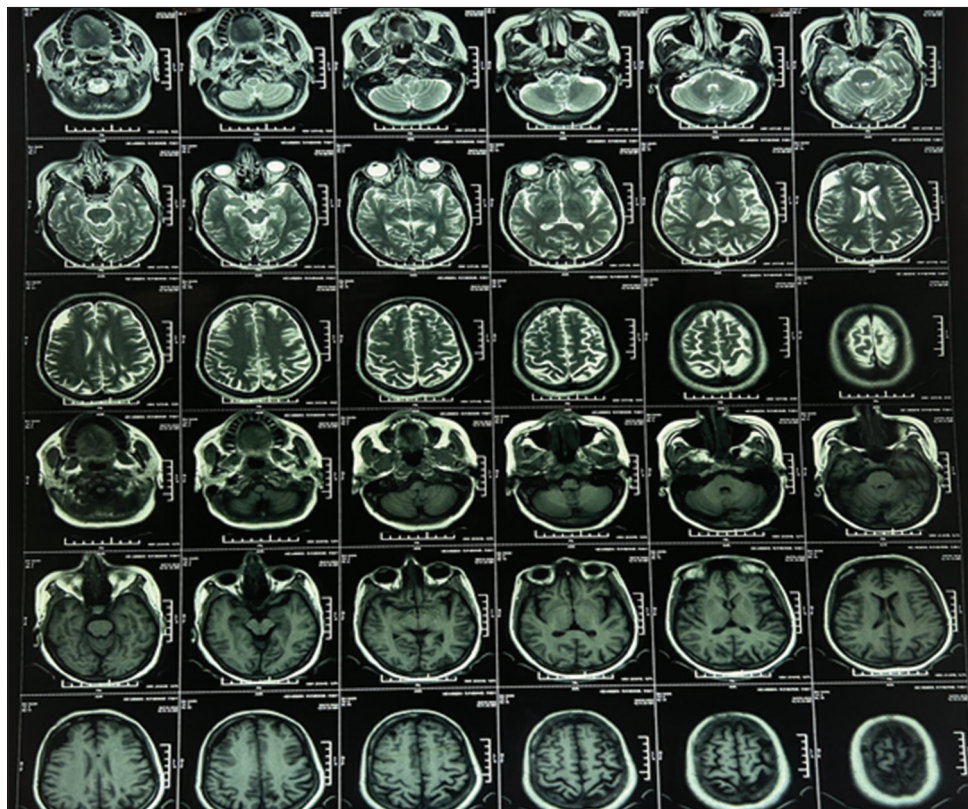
Magnetic resonance imaging of the brain showing hyperintense areas in the left lateral medulla and cerebellum, consistent with acute infarction. Note the additional involvement of the capsulo-ganglionic region
